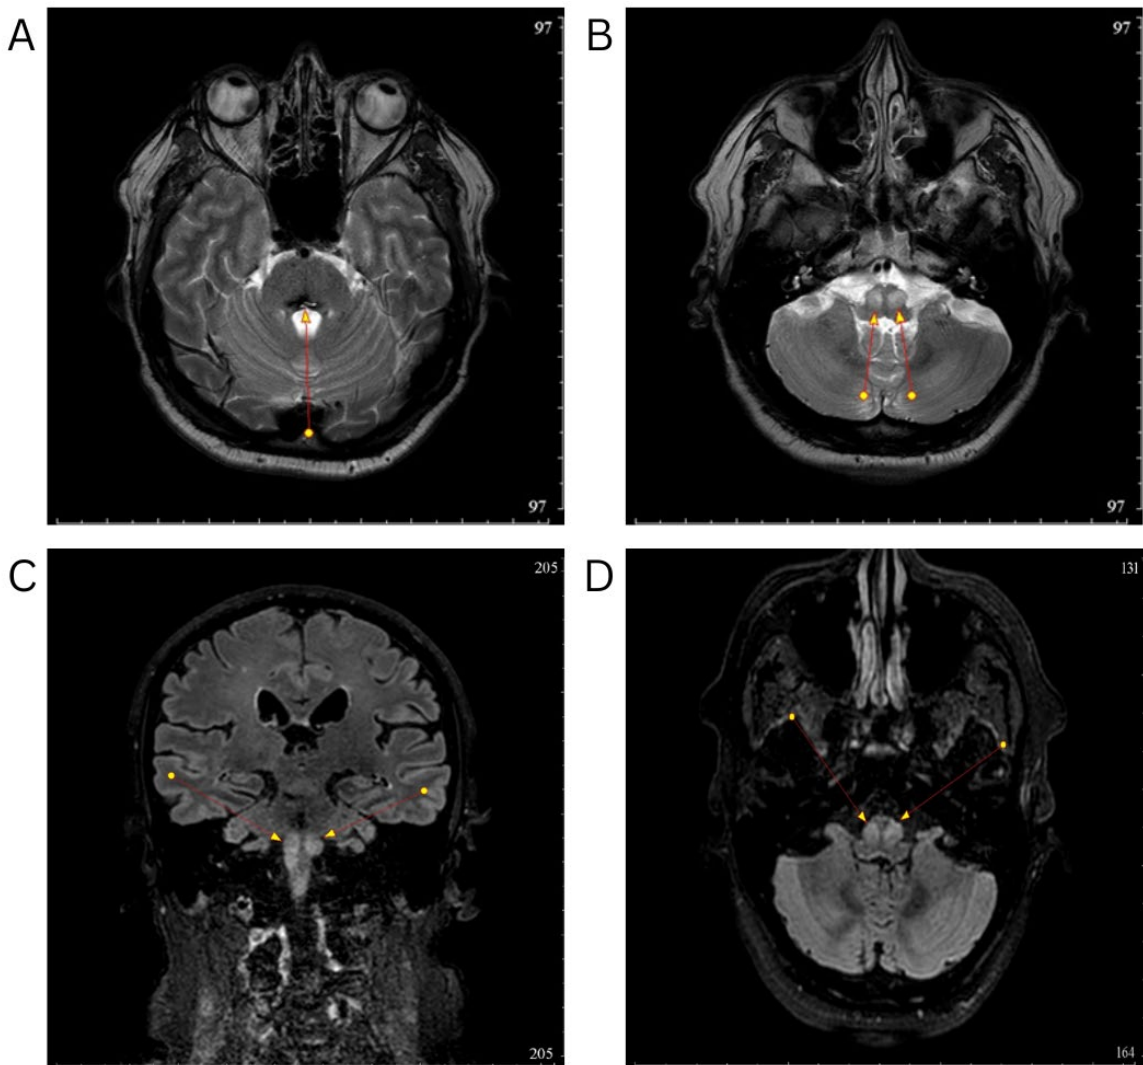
A: MRI showed images in coronal T1w, B: frontal T1w, C: coronal T2w, and D: frontal T2w, pons is decreased in size and post-hemorrhagic cystic mass (9×3×10 mm) with hemosiderin deposits in the tegmentum and bilateral area of high signal intensity observed in the T2w MR image (15×6 mm)
